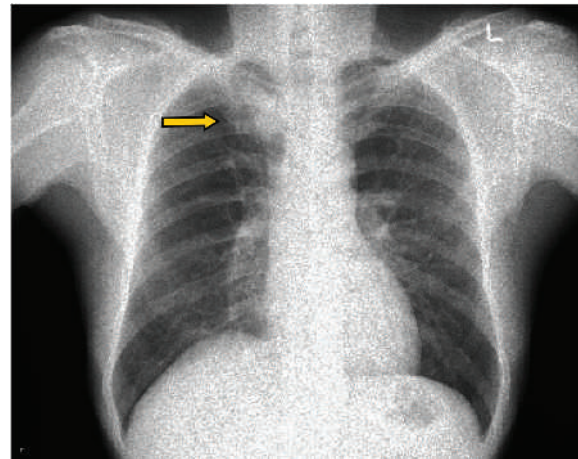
Chest radiograph showing homogenous opacity in the right paratracheal region
